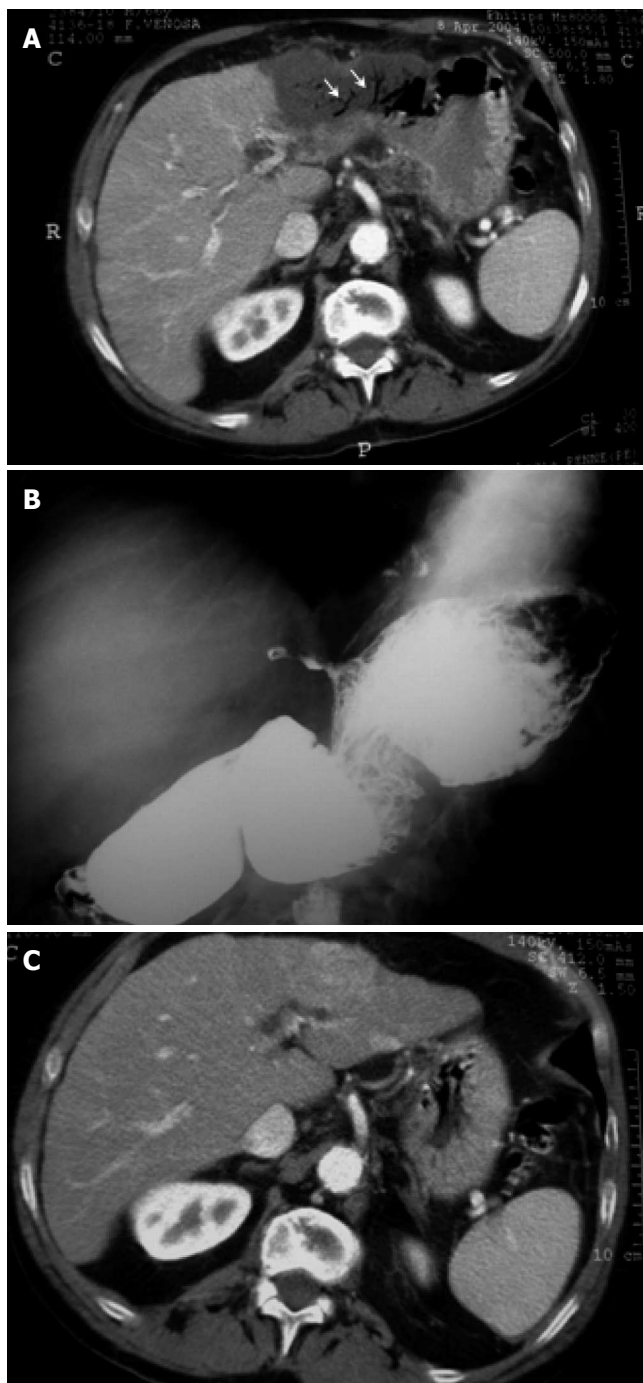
Enhanced CT abdominal scan performed after the percutaneous procedure showing air inclusions in the bile ducts within the left portion of the liver (A), radiograph of the first gastrointestinal tract showing a biliary gastric fistula starting from the lesser curvature of the stomach with concomitant spasm of the greater curvature (B), and enhanced CT scan of the abdomen performed before percutaneous thermal ablation of the HCC lesion in the III liver segment showing a left portion of the liver without aerobilia (C).
